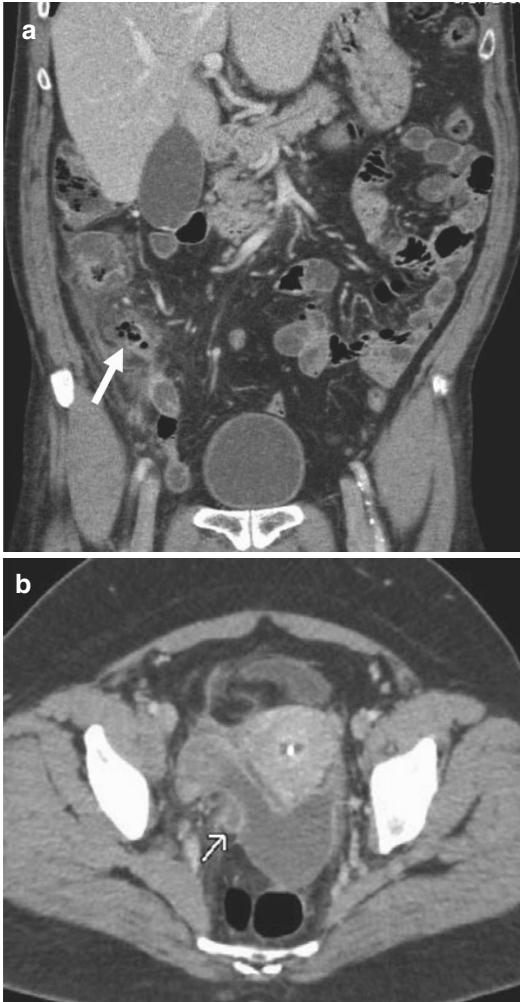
(a) Perforated appendicitis with extraluminal air seen on the abdominal CT (*arrow*) (CT computed tomography), (b) perforated appendicitis with associated abscess formation (*arrow*), (c) acute appendicitis with inflammatory phlegmon (*arrowheads*)
